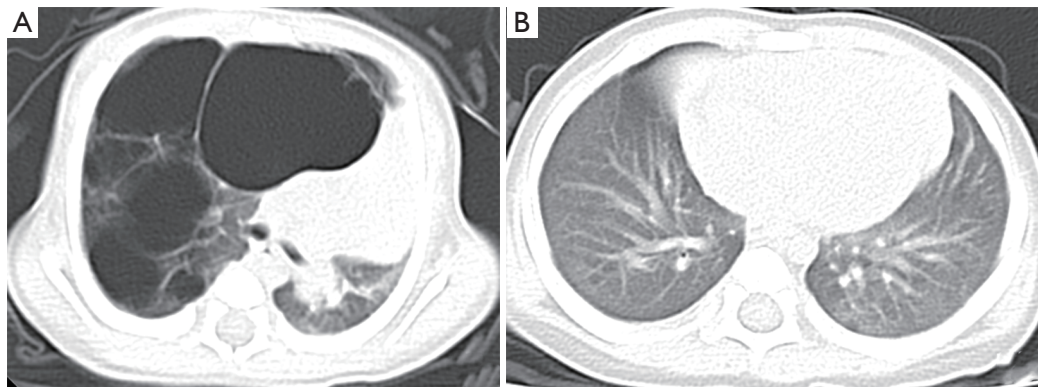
A 13-day-old boy with CPAM in the upper lobe of the right lung, Stocker type 1. CT plain scan images showed that: (A) the giant vesicle caused the heart to move to the left; (B) 1 year after resection of the upper lobe of the right lung, there was no residual lesion, and the heart returned to its original position. CPAM, congenital pulmonary airway malformation; CT, computerized tomography.
